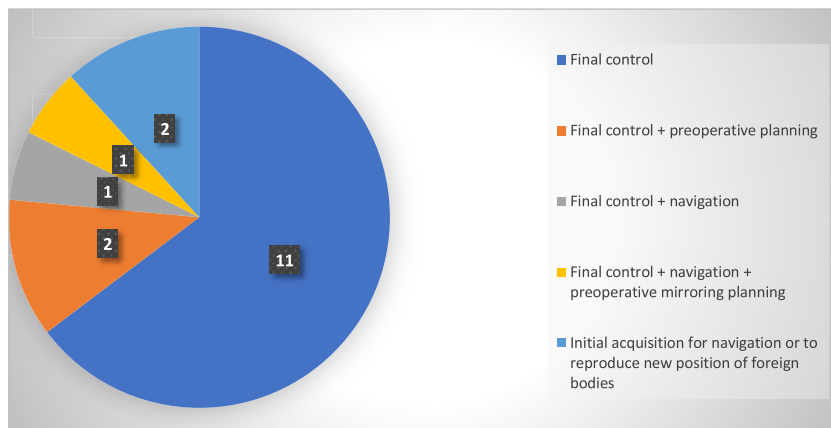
Number of articles according to the different uses of intraoperative CBCT.
